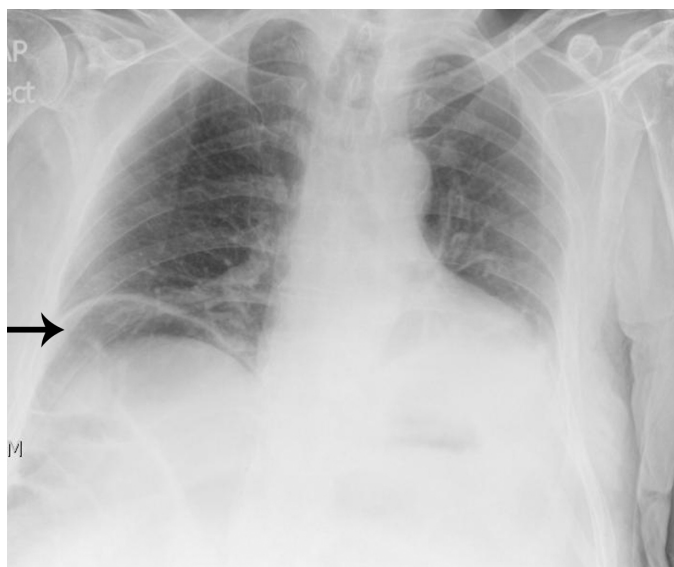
Chest radiograph suggestive of a pneumoperitoneum, with an elevated right hemidiaphragm and subdiaphragmatic free air.
